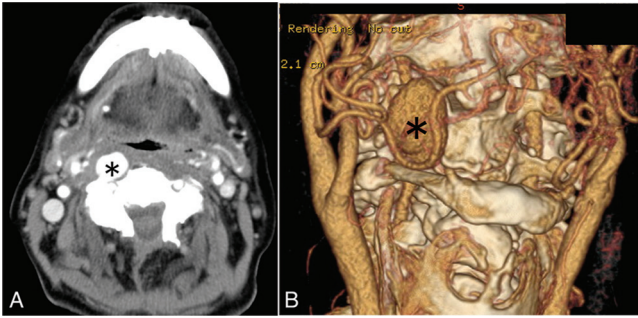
Contrast-enhanced computed tomography (CT) and CT angiography show a large aneurysm (*asterisk*) of the right extracranial vertebral artery. A: Axial view of enhanced CT. B: Frontal view of CT angiography.
